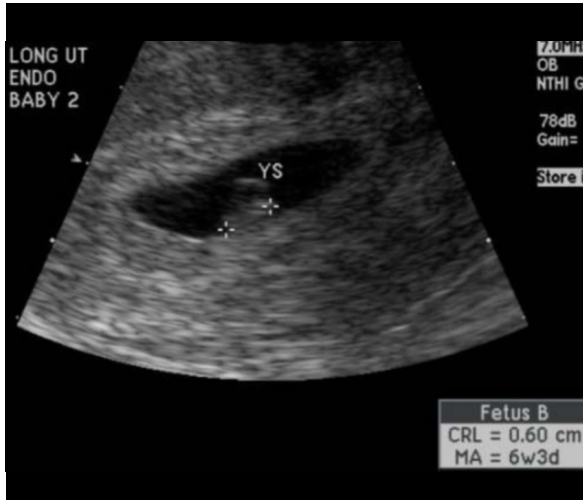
37-year-old woman with heterotopic pregnancy. At presentation, transvaginal ultrasound of the uterus showing an intrauterine gestation with a crown-rump length (CRL) of 6 mm corresponding to a 6 week 3 day gestation.
